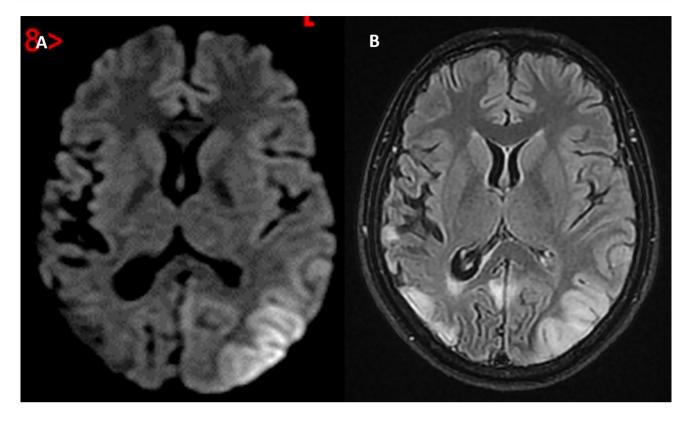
a Axial diffusion-weighted image (DWI) shows restricted diffusion in the left temporo-parieto-occipital junction. b Axial fluid-attenuated inversion recovery (FLAIR) image reveals increased signal intensity in the same territory as on the DWI, and mirrored sequelae on the right
